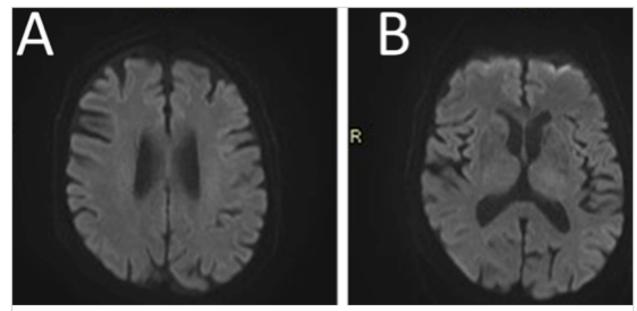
1.5T brain MRI with diffusion weighted sequences showing the lack of diffusion restriction in the left frontal cortex (part A) and the thalamic region (part B), proving that the edema is of vasogenic nature.
